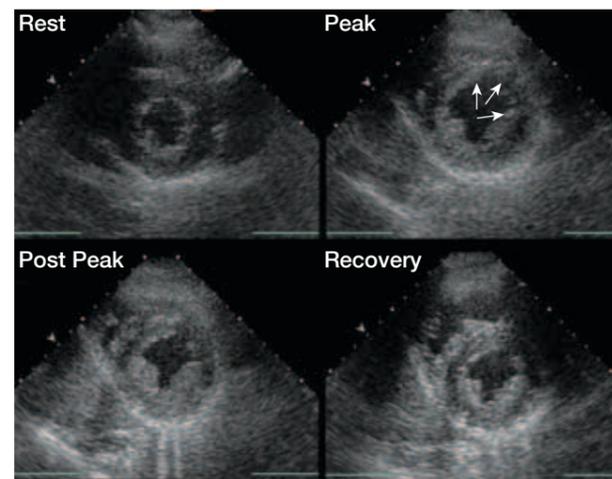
These end-systolic still frame images shown in a quad-screen format were recorded from the parasternal short axis view at the papillary muscle level. These images show a normal exercise response; observe that the LV cavity decreases in size and the walls become hyperdynamic at peak exercise (*top right*).
